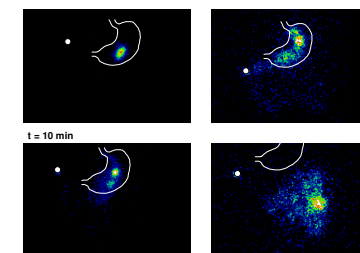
Representative scintigraphic images (subject 7) showing gastric emptying of both formulations in the fasted state
